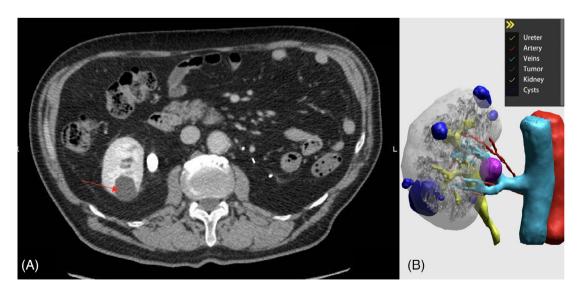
A, CT scan of the right renal tumor, the arrow points the lesion; B, DocDo three-dimensional reconstruction of 2D CT images
